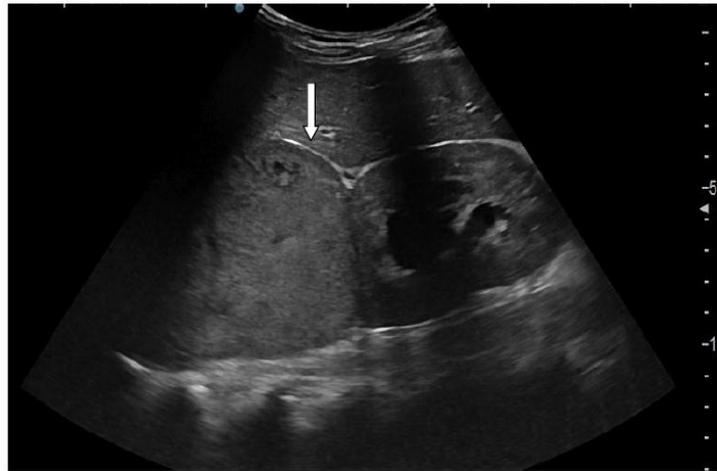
Abdominal ultrasound demonstrating right adrenal pheochromocytoma; arrow indicate large heterogeneous mass.
